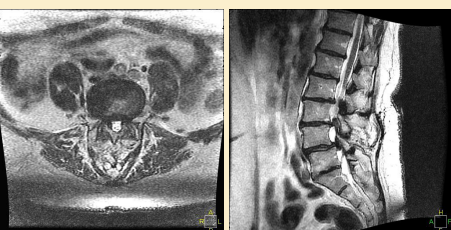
Pre op sagittal and axial (L4-5) MRI showing moderate to severe central stenosis at L2-3, and severe stenosis at L3-4 and L4-5 as well as associated foraminal narrowing.
